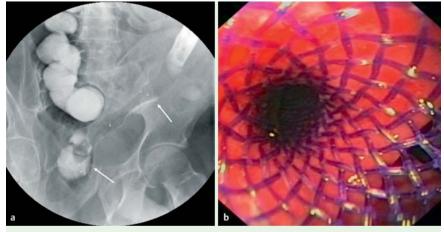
Appearance of the biodegradable stent immediately after insertion, visualized by use of: a plain abdominal radiograph (arrows indicate the stent in place) and b endoscopy.
